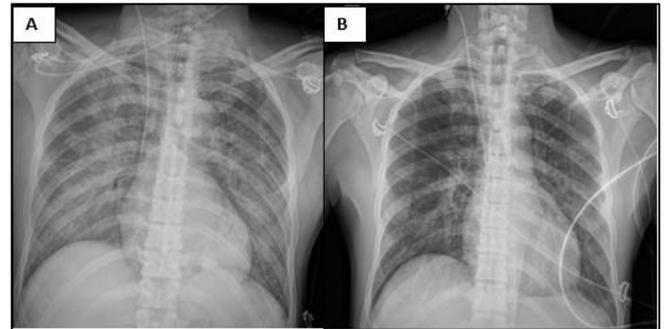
(Panel A-B): Chest x-ray at time 0 (Panel A) and subsequent check-up after 7 days (Panel B), where there is a clear reduction in the subtle and widespread pulmonary consolidations is documented
